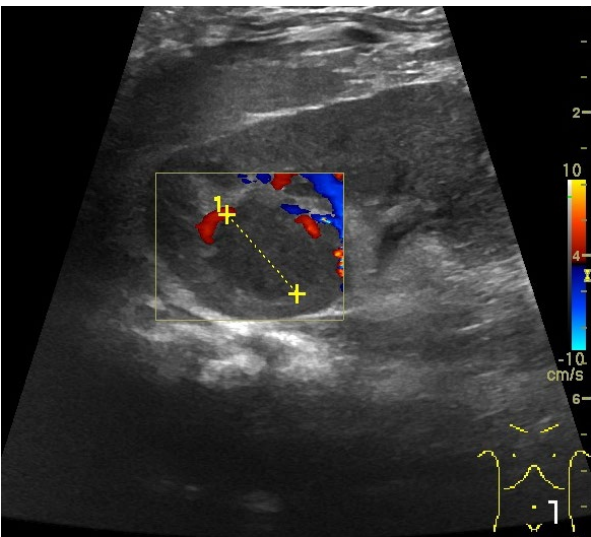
Image with Color Doppler – no central vascularity, visible vascularization on the periphery of the abscess capsule
